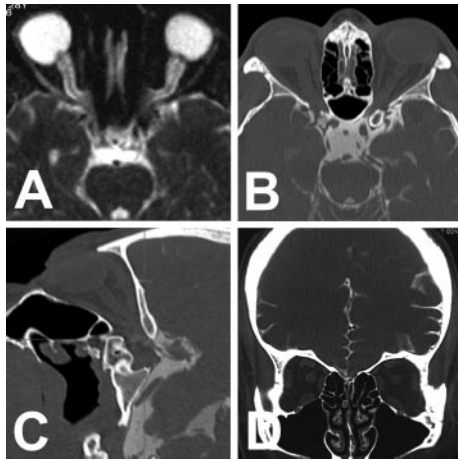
(A) T₂ sequence of MRI demonstrates fluid congestion in the SAS of both optic nerves. Note flattening of the posterior sclera and papilloedema in both eyes. (B and C) CT-cisternography, axial/sagittal view: Distinct CLCSF in all intracranial CSF spaces. Note, full filling in the chiasmatic cistern. (D) Coronal CT-cisternography does not show CLCSF in the SAS of both SAS of the optic nerve. The CT-cisternography shows an extension of the optic nerve shape with stasis of contrast agent loaded CSF at the level of the distal optic nerve sheath immediately before the optic canal.
